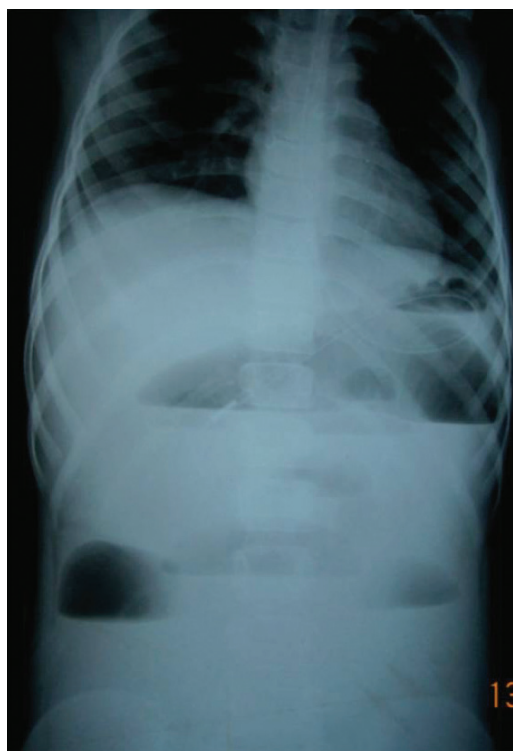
Plain Xray abdomen erect showing obstructed pattern.
